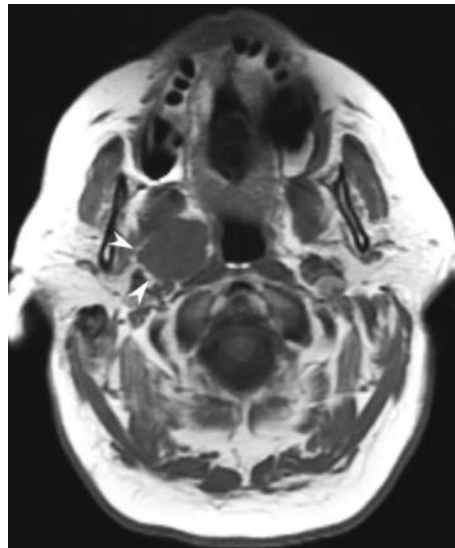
Axial unenhanced T1-weighted image through the PPS demonstrates a 3-cm parapharyngeal mass separated from the deep lobe of the parotid by an intact fat plane (*arrowheads*). This mass, which displaces the fat plane medially, was excised and shown to be a pleomorphic adenoma
